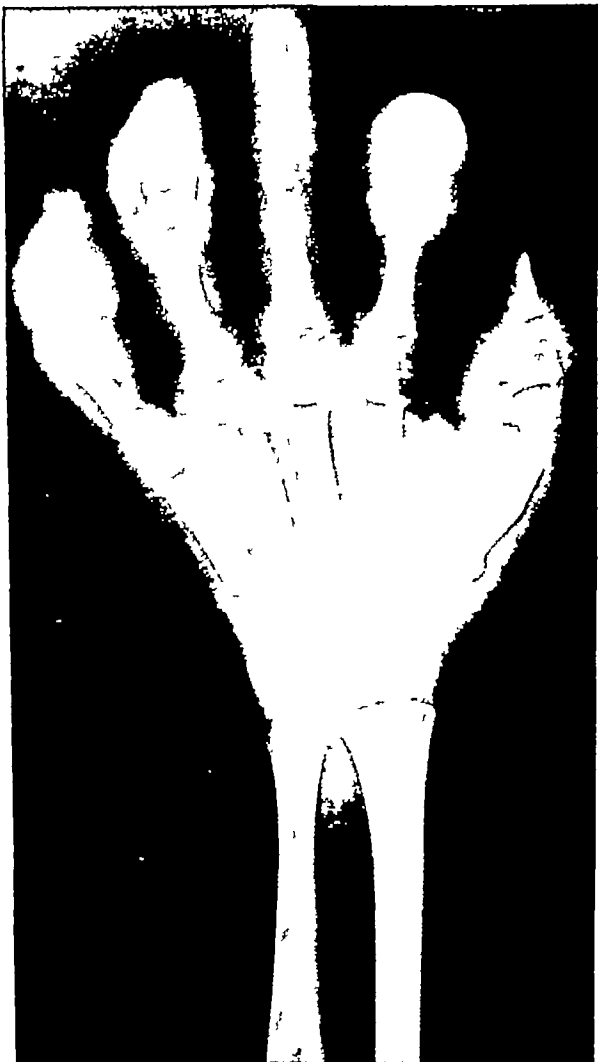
Left hand of 3-year-old Negro with proved tuberculous osteitis involving skull, ribs, and many tubular bones. The mutilating destructive foci in the metacarpals and phalanges are strikingly similar to those seen in certain instances of sarcoidosis. Other bones, however, showed extensive periosteal new bone formation. Patient had numerous draining sinuses, and a positive tuberculin reaction. At autopsy, caseation necrosis was found in the bone lesions and tubercle bacilli were cultured from caseous material removed from mesenteric lymph nodes. (Roentgenogram, courtesy of Dr. H. H. Brueckner, Canton, Ohio.)
